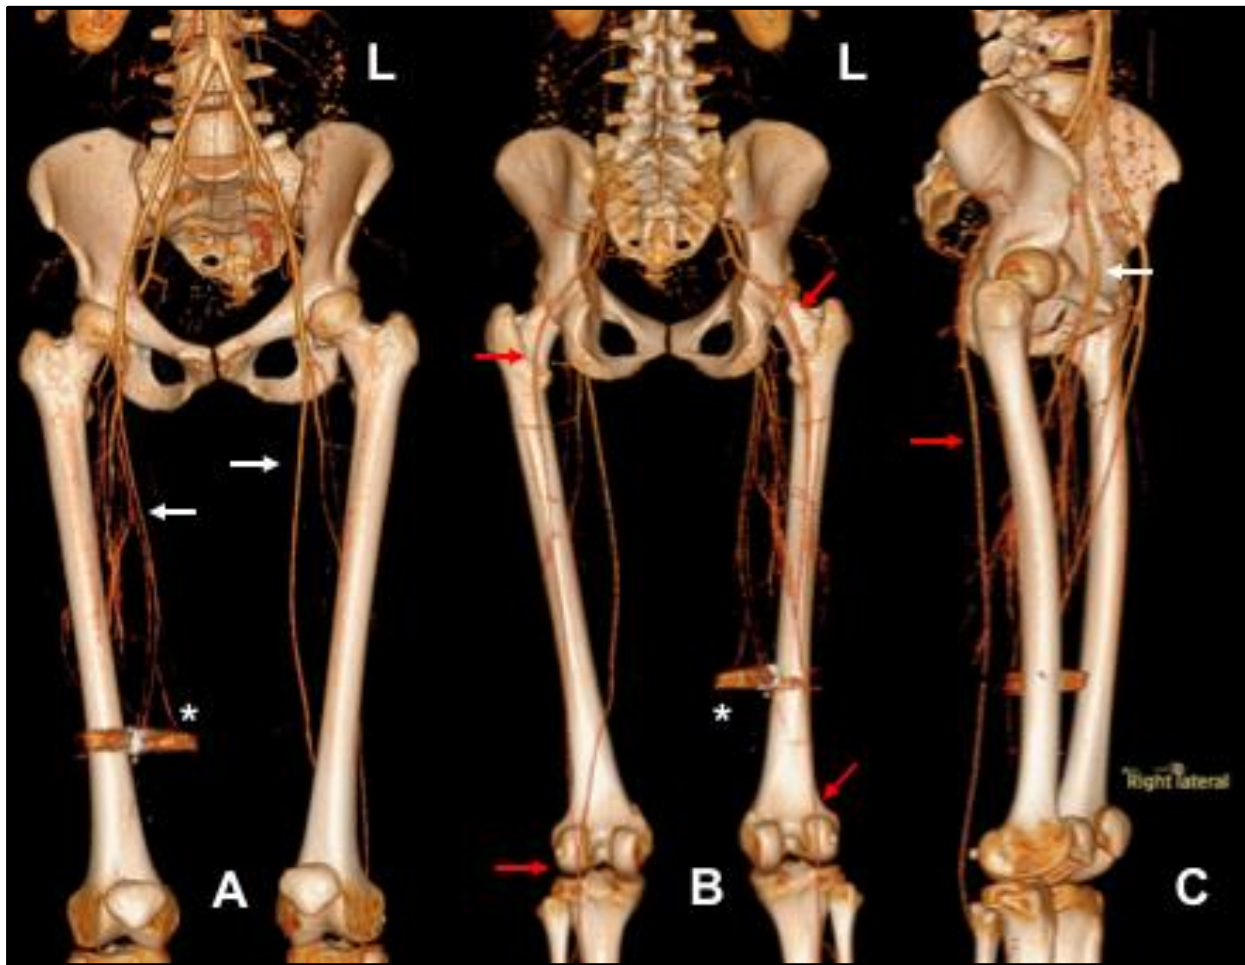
(A) Anterior coronal CTA 3D volume reconstruction demonstrating normal origin and course of the SFAs (white arrows), from the common femoral arteries. The SFAs were found to be hypoplastic, particularly within the right thigh, and demonstrated poor continuation to the popliteal arteries. Bullet fragment denoted by the asterisk (*). (B) Posterior coronal CTA 3D volume reconstruction demonstrating the bilateral PSAs originating from the internal iliac arteries, continuing as the popliteal arteries (red arrows). (C) Lateral oblique 3D volume reconstruction shows the relationship of the posteriorly orientated PSA (red arrow) relative to the anteriorly located SFA (white arrow).
